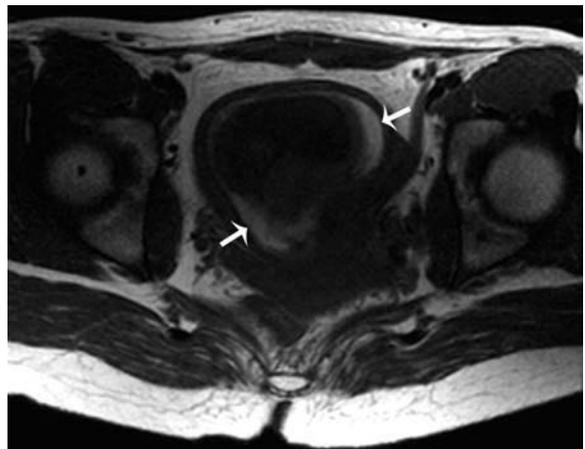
Subchorionic hematoma in a 27-year-old pregnant female. Axial T1-weighted 2D-SPGR image reveals high T1 signal intensity material (arrows) in the subchorionic location.
